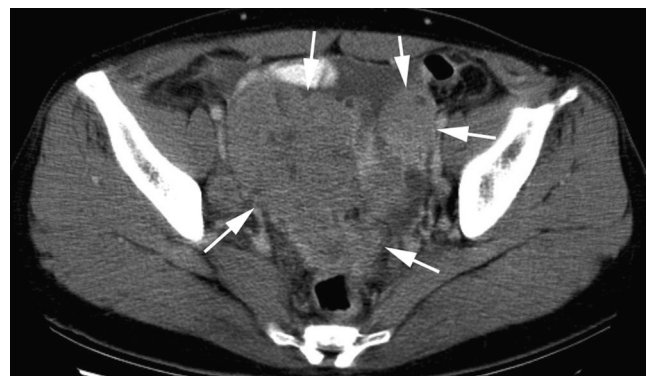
46-year-old female patient with poorly differentiated ovarian carcinoma. Transverse CT image shows two masses involving bilateral ovaries (arrows). Both masses show solid nature.
